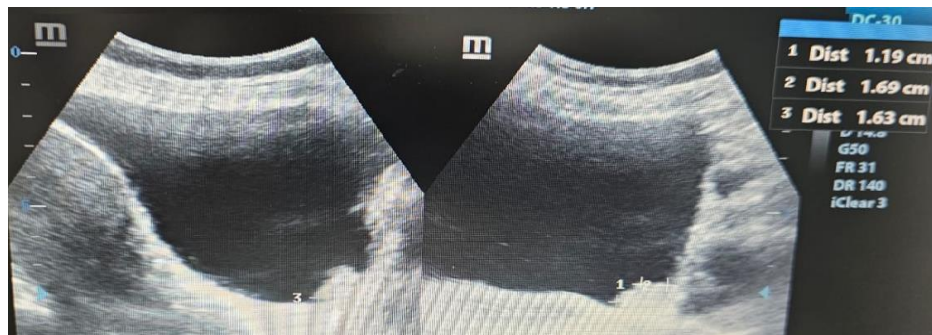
Ultrasound scan demonstrated a mass on the left lateral wall of the bladder, measuring 1.19 cm × 1.69 cm × 1.63 cm
